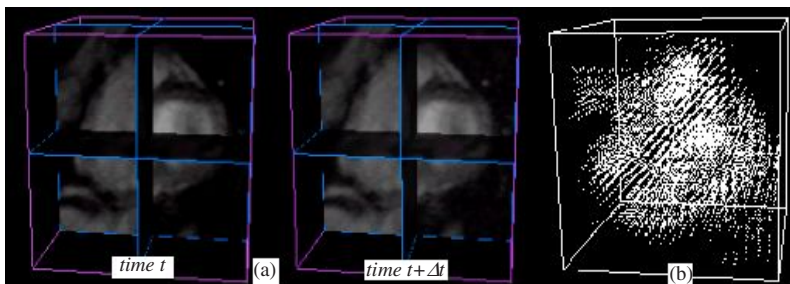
(a): 3D MRI interpolated data volumes (2 successive instants). (b): 3D velocity field
